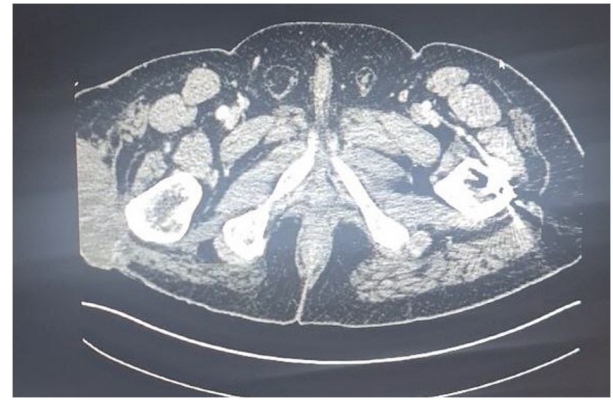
CT axial view of the tumor (2020). CT, computed tomography.
